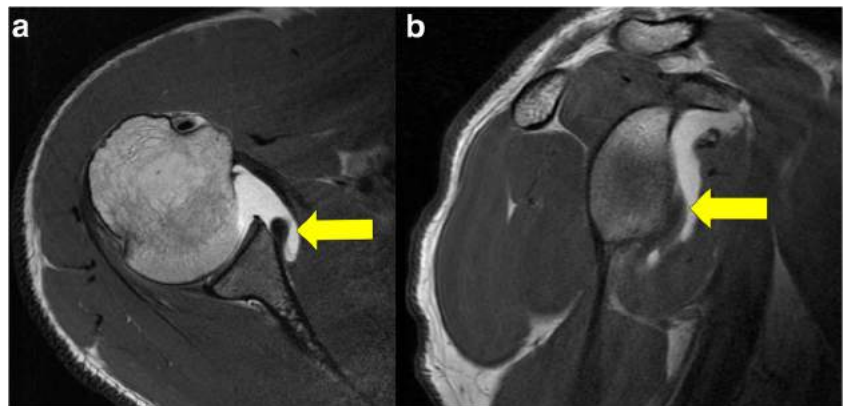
Anterior labral periosteal sleeve avulsion (ALPSA) (arrow) by an MRI axial proton density (a) and sagittal T1 (b)
